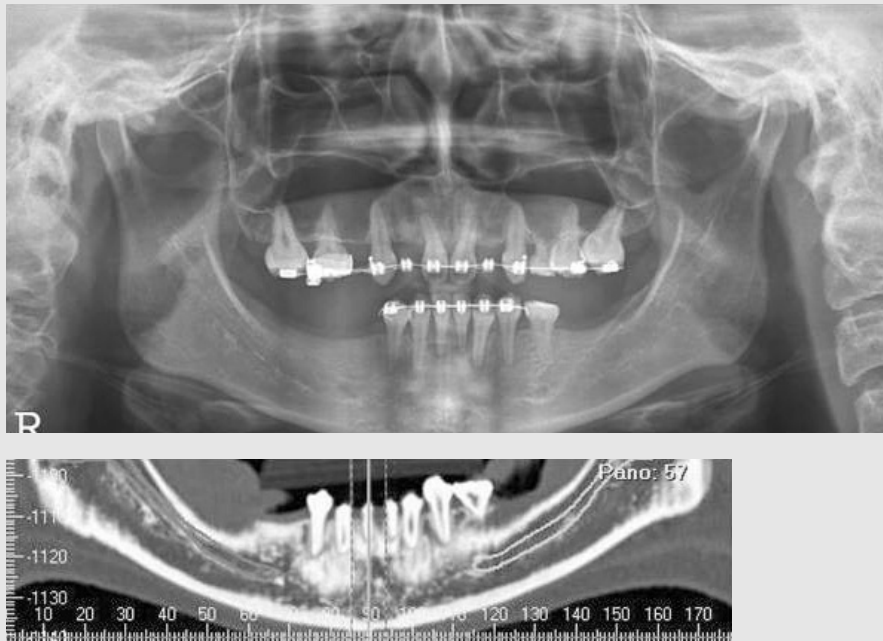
Radiographic image at first visit.
